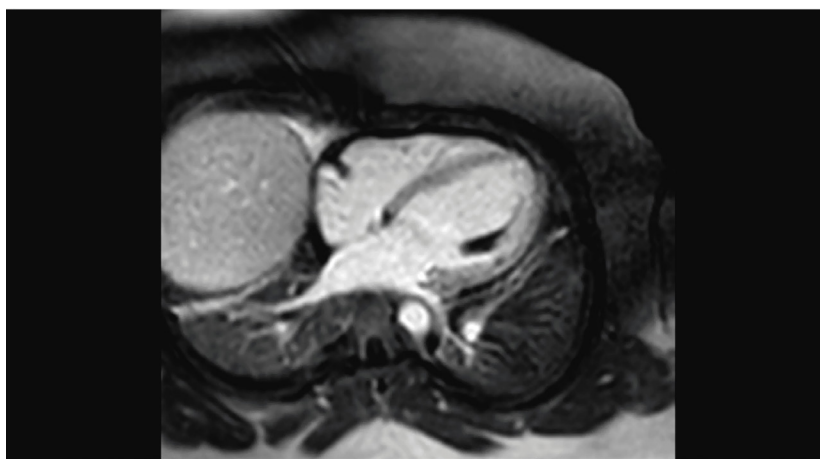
Cardiac magnetic resonance imaging. Perfusion sequences showing a perfusion defect of the anterolateral (red-arrow) and posteromedial (blue-arrow) papillary muscles (A), as well as in the mid-segment of the anterolateral wall (red-arrow on B). Subendocardial Late Gadolinium Enhancement (LGE) at the basal segment of the anterior wall (red-arrow on C). STIR-T2 sequence showing myocardial edema in the anterolateral papillary muscle (red-arrow on D).
